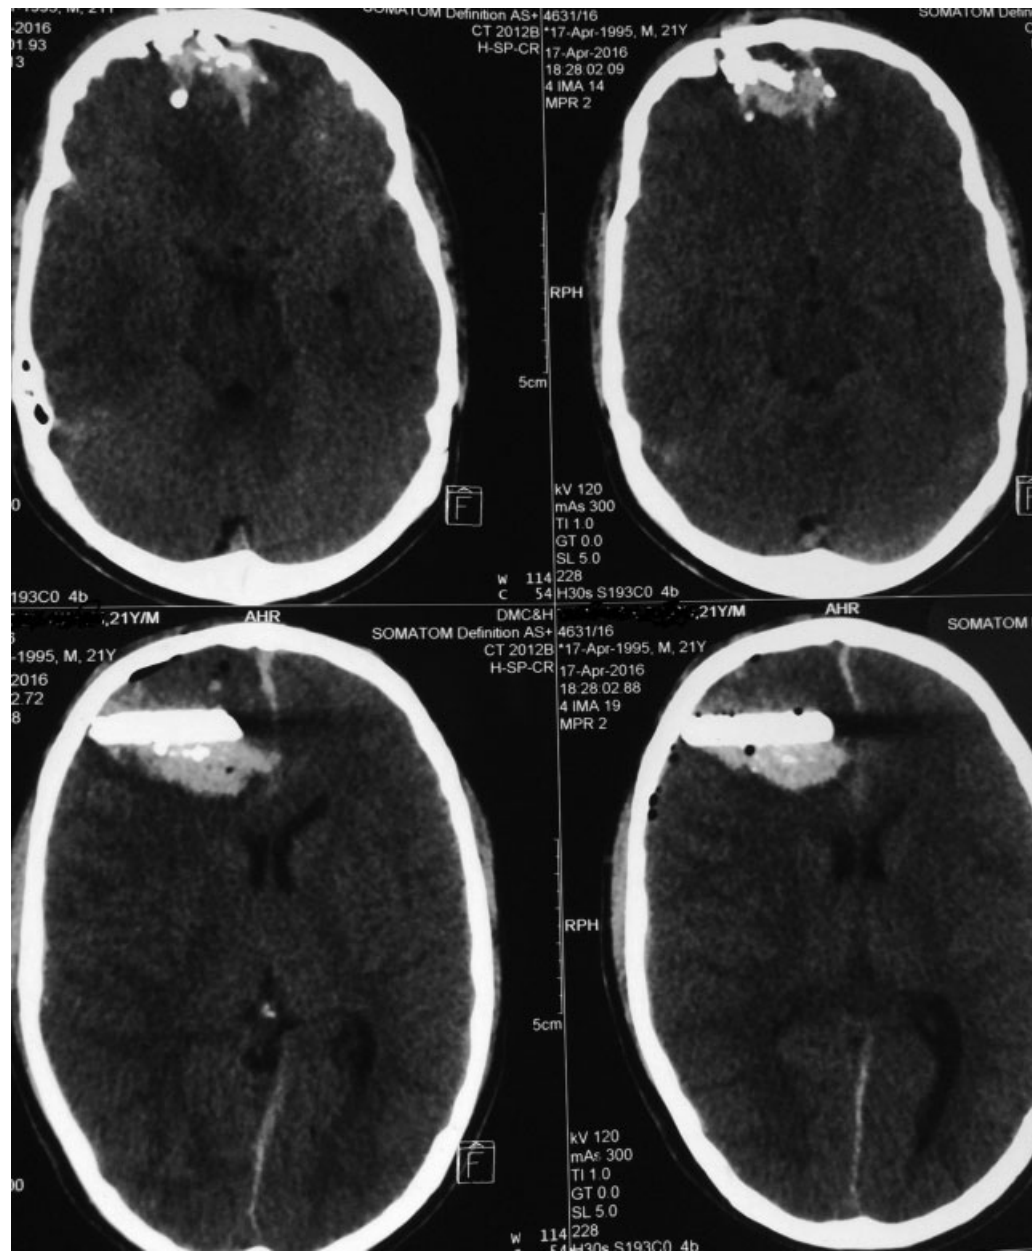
Computed tomography scan of the head revealing right frontal intracerebral foreign body along with hematoma.
